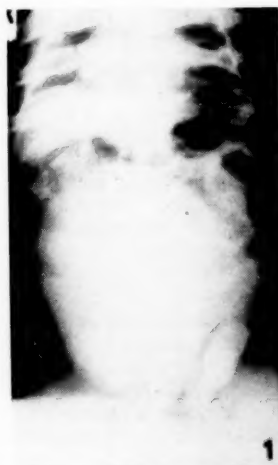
X-ray of patient.
